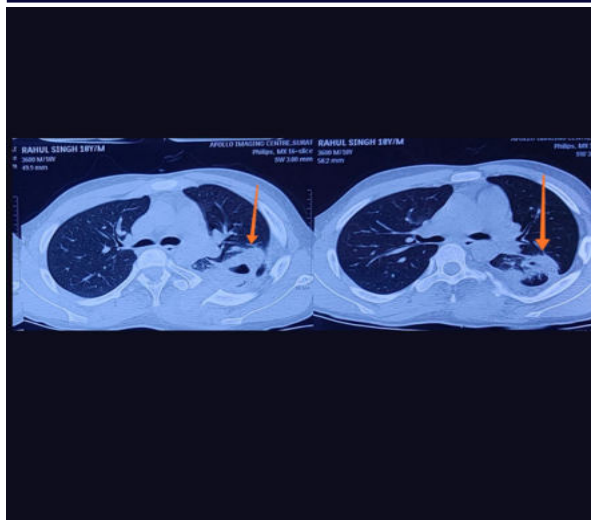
Axial Section Of The CT Thorax With Yellow Arrow Showing Consolidation With Cavitation In Left Upper Lung In Lung Window Settings.
